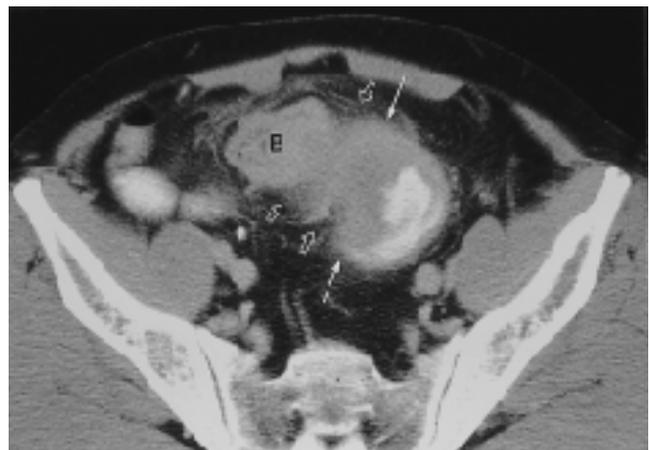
The gastrografin enema CT scan shows a eccentrically thickened anterior right lateral sigmoid colonic wall(arrow) with direct invasion into adjacent bladder suggesting T4. A thickening of the bladder wall and perivesical infiltration(open arrow) is seen. Pathologic examination revealed tumor invasion into the pericolic fat and adhered paravesical fat tissue (T4).(B= Bladder)
